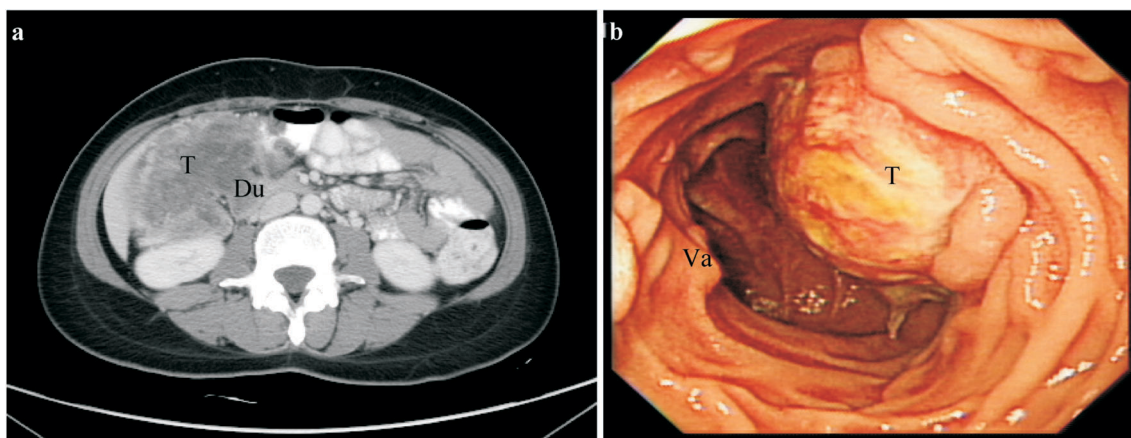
Demonstration of one case with duodenal invasion on CT scan (a) and PES (b) in pre-operative image evaluation. T: Tumor; Du: duodenum; Va: papilla of Vater.
